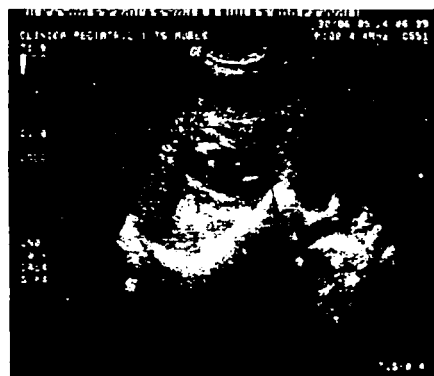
Portal cavernoma– Doppler ultrasound aspect
